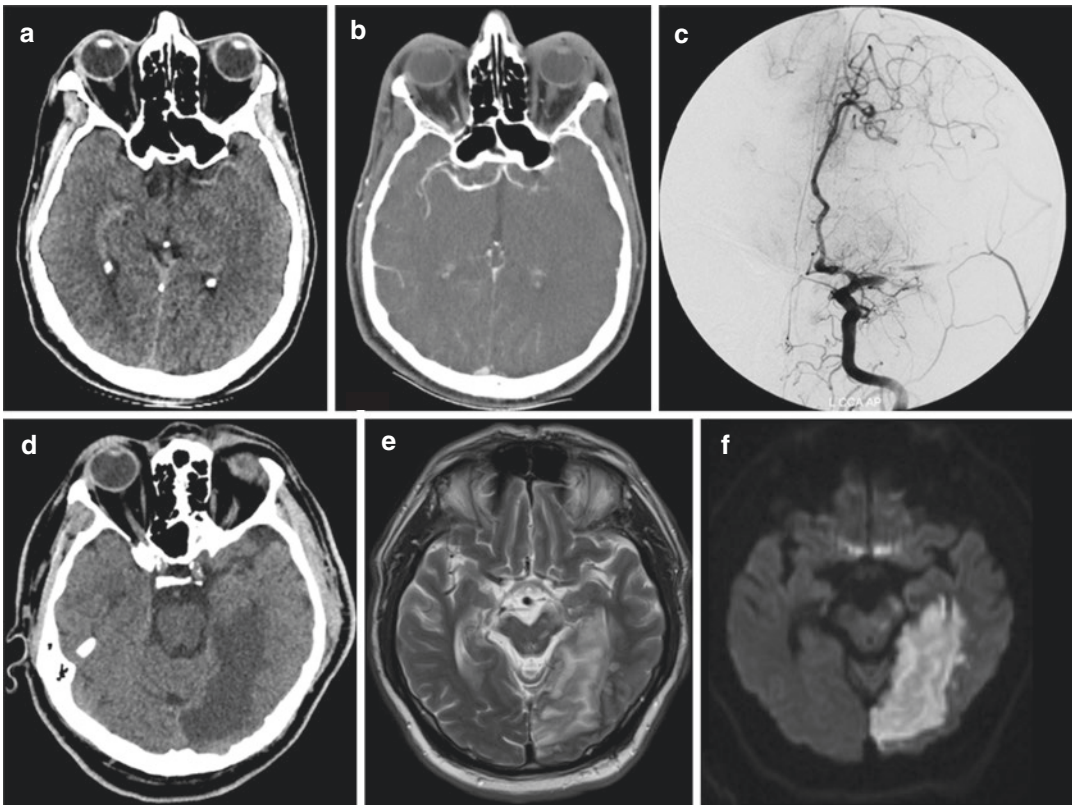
Stroke signs on NCCT: (a) Left-sided dens MCA sign, increased density on the left MCA M1 segment related to the acute thrombus in the lumen, (b) CTA image shows no contrast filling in the left M1, (c) DSA demonstrates thrombus on the left M1 segment, (d) parenchymal hypodensity and loss of grey-white matter differentiation
